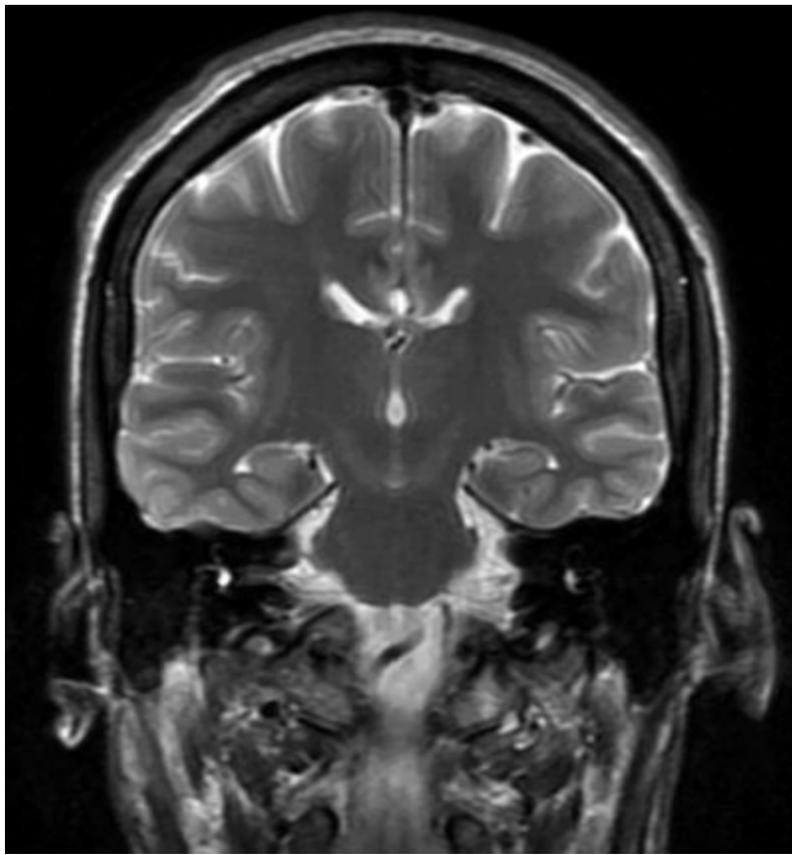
Coronal T2 magnetic resonance image showing division of the posterior body of the corpus callosum. Note the position of the fornices below the corpus callosum.
